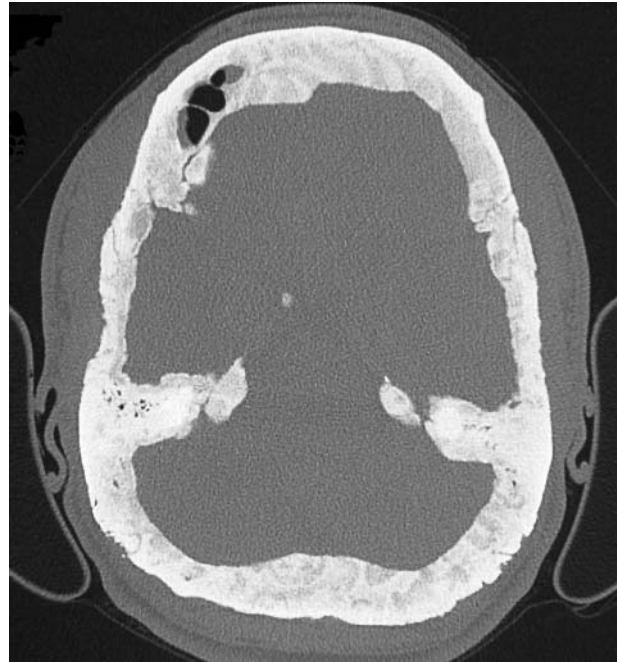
Axial computed tomography (bone window) of the head of a patient from family 10, showing extensive sclerosis and thickening at the calvaria and petrous bones with loss of the diploe. Note also obliteration of the left frontal sinus.
